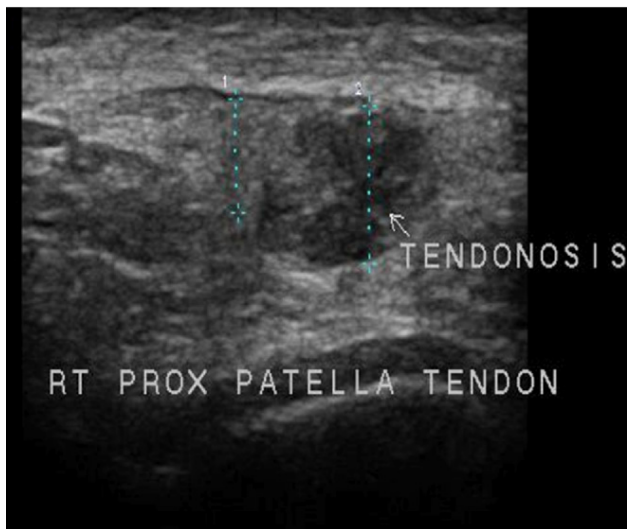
Long-axis view of a right partial patellar tendon tear on ultrasound imaging.
